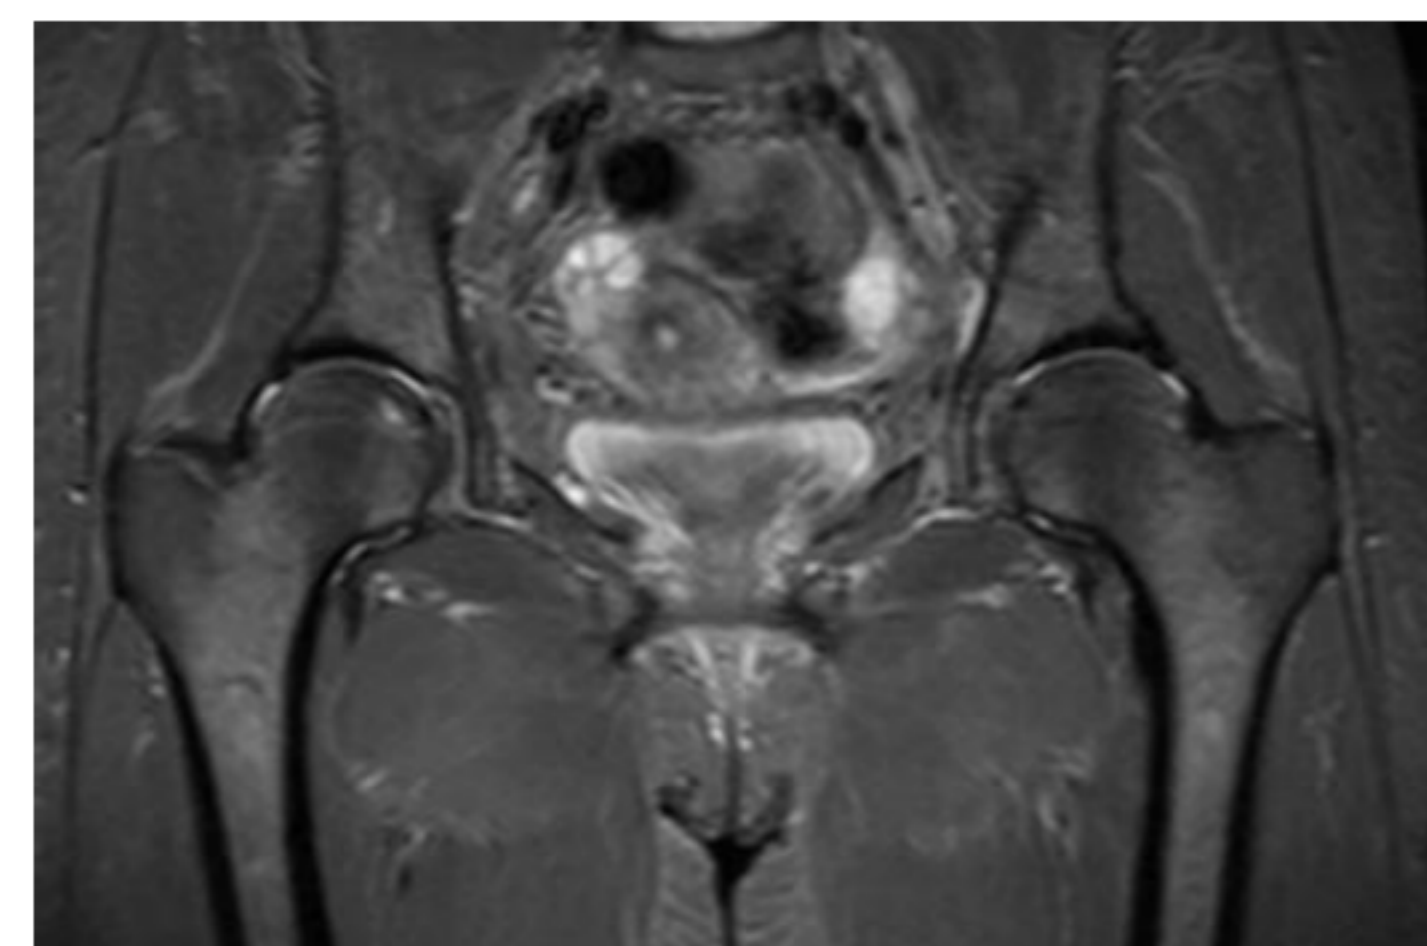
Post-treatment MRI pelvis coronal STIR
